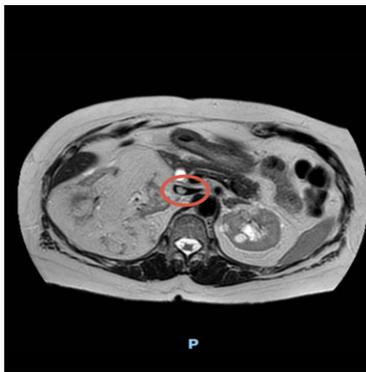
Axial abdominal MRI confirming the bulky right renal angiomyolipoma with inferior vena cava involvement and mass effect on adjacent structures.
